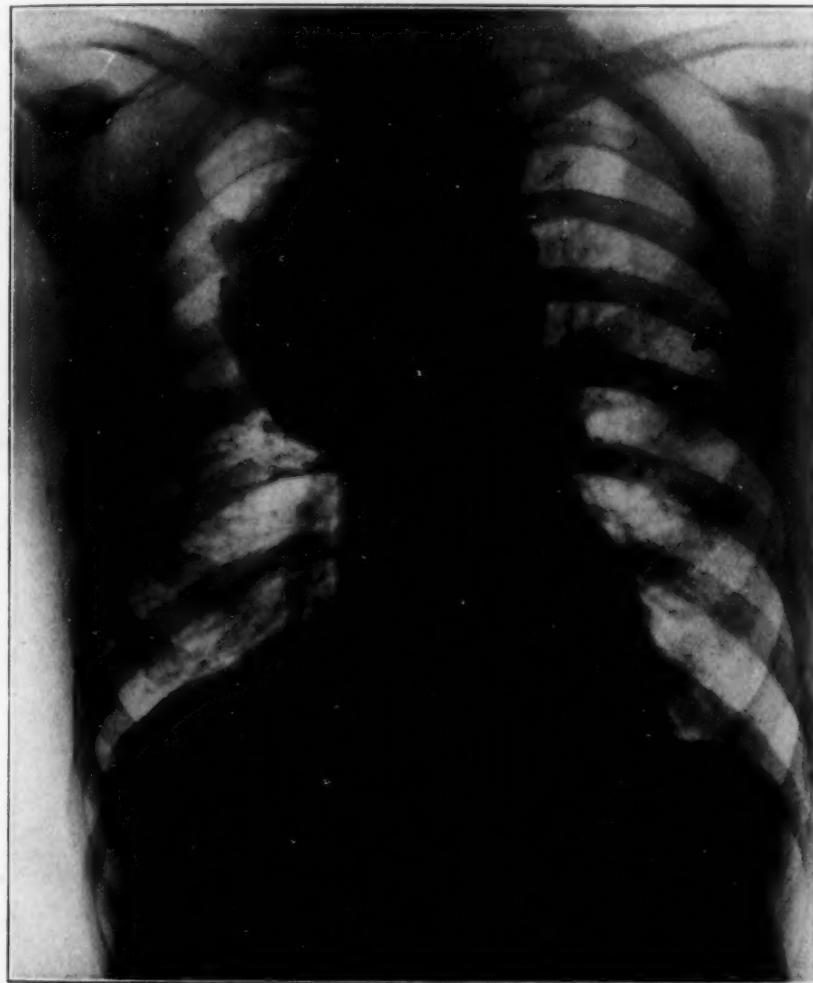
Roentgenogram of mediastinal carcinoma.
